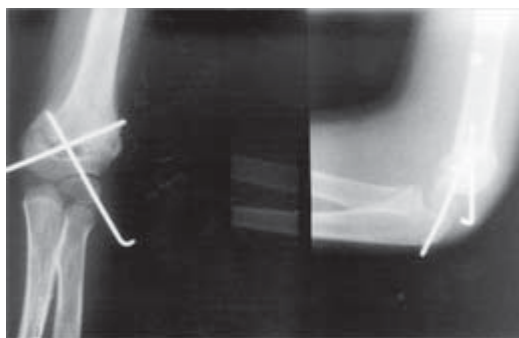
Anteroposterior and lateral radiographs of the supracondylar humerus fracture subsequent to percutaneous cross-pinning. The medial pin is not placed posteriorly near the ulnar groove and acutely to the long axis of the humeral shaft.
